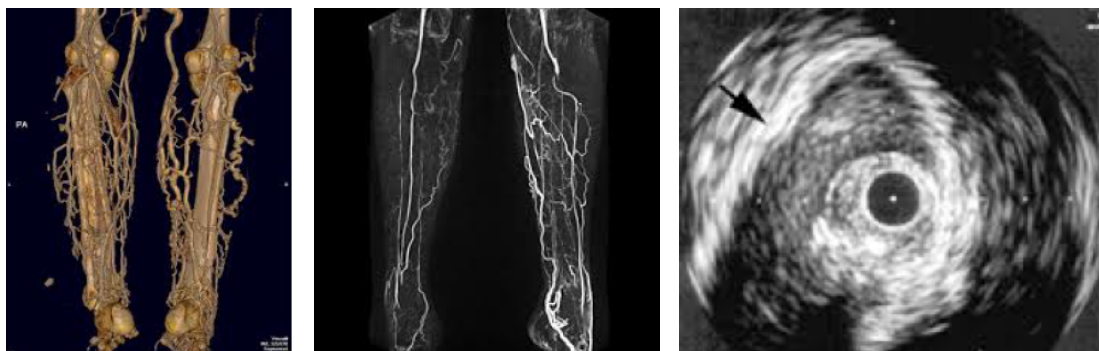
CT Venography, MR Venography, IVUS
